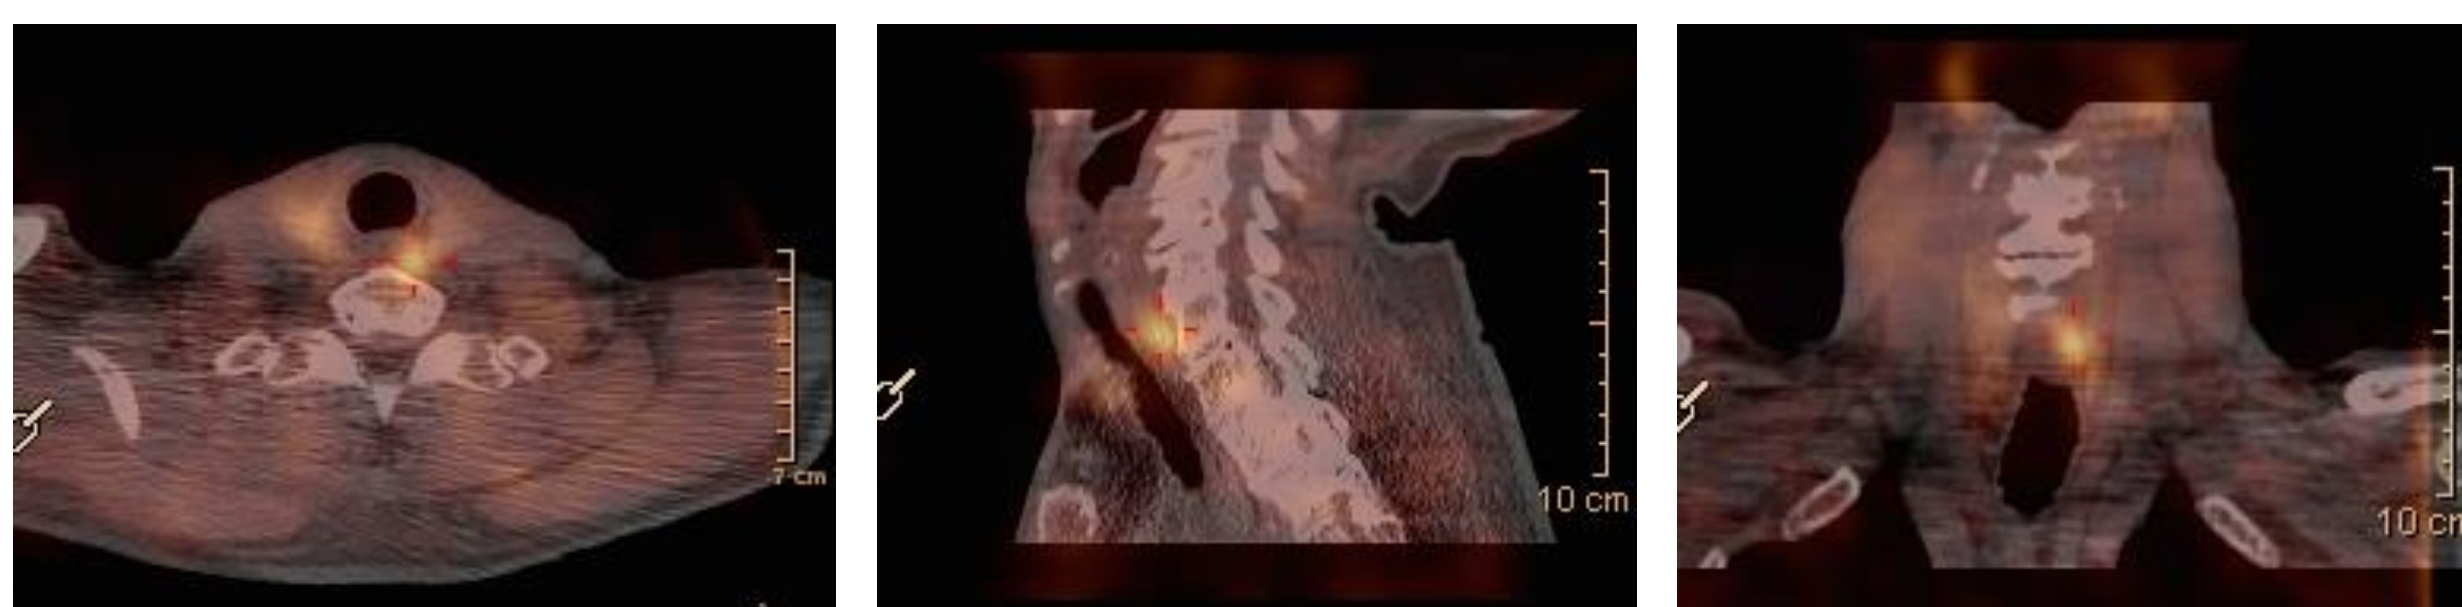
Sagittal, and coronal views that SPECT gives to help localize the abnormal left inferior parathyroid gland in multiple dimensions
